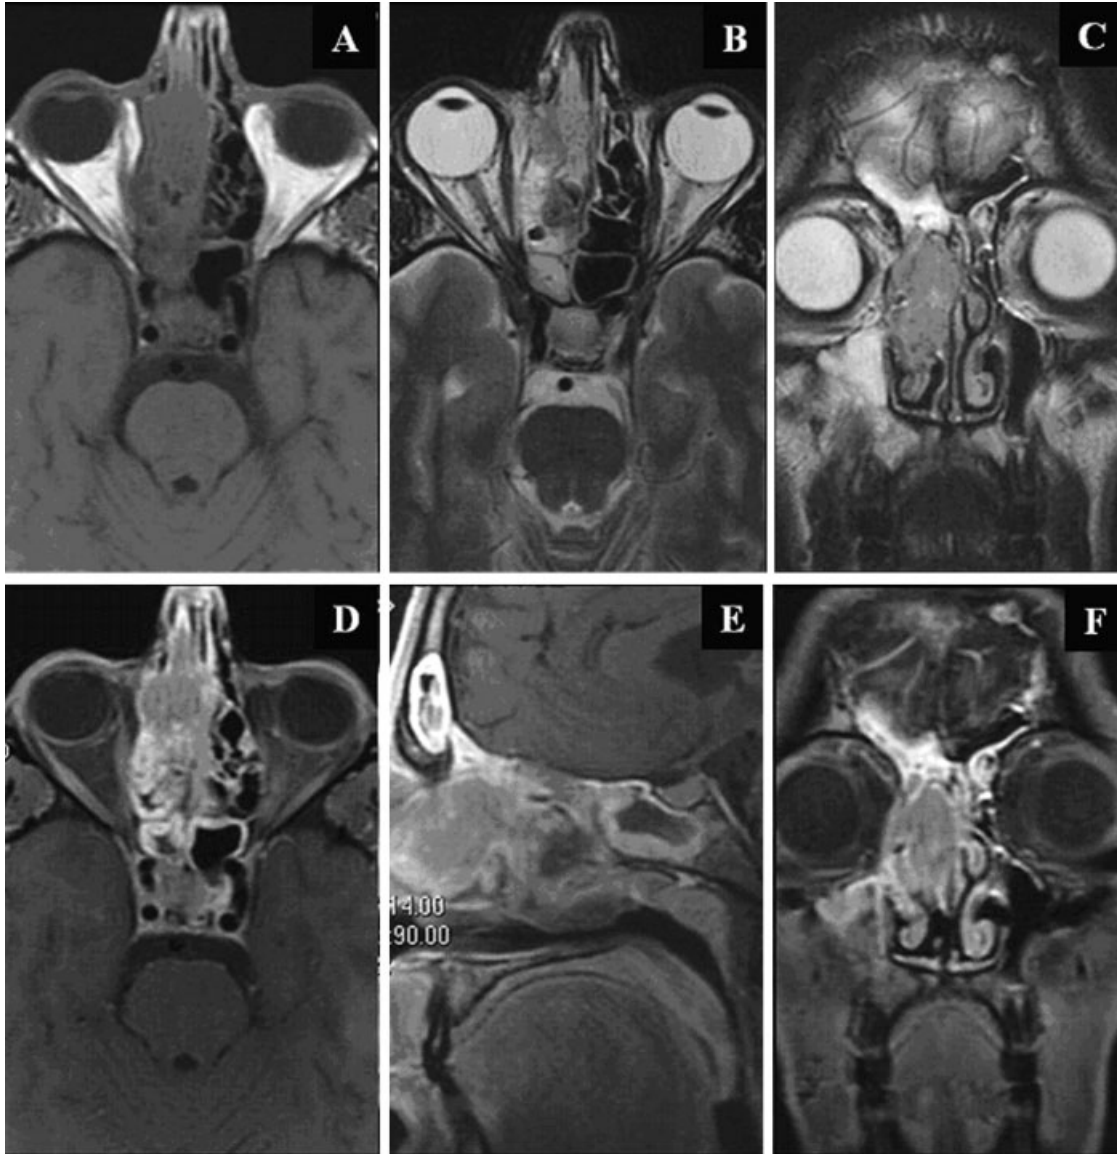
Preoperative MRI: (A) Axial T1-weighted images without contrast; (B) Axial T2-weighted images; (C) Coronal T2-weighted images; (D) Axial fat-saturated T1-weighted images after contrast; (E) Sagittal fat-saturated T1-weighted images after contrast; (F) Coronal fat-saturated T1-weighted images after contrast. The tumor fills almost completely the upper right nasal cavity and ethmoid, reaching the cribriform plate but without intracranial involvement; there was initial involvement of the medial wall of the right orbit, with displacement of the retrobulbar orbital fat but without evidence of extension into the orbit. The tumor showed relatively low signal on T2-weighted images and moderate enhancement due to its high cellularity. Combination of T2-weighted and postcontrast fat-saturated T1-weighted images allowed good differentiation between the tumor itself and the associated reactive/obstructive findings in the right maxillary, frontal, sphenoid sinuses.
